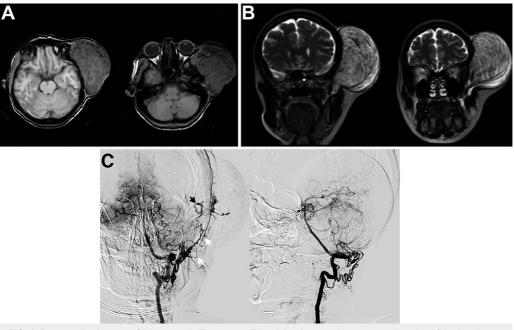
Preoperative images of the tumor. A: Transverse T1-weighted magnetic resonance imaging of the head shows a giant extracranial homogeneous mass with rich vasculature compressing the left frontal and parietal bones.
